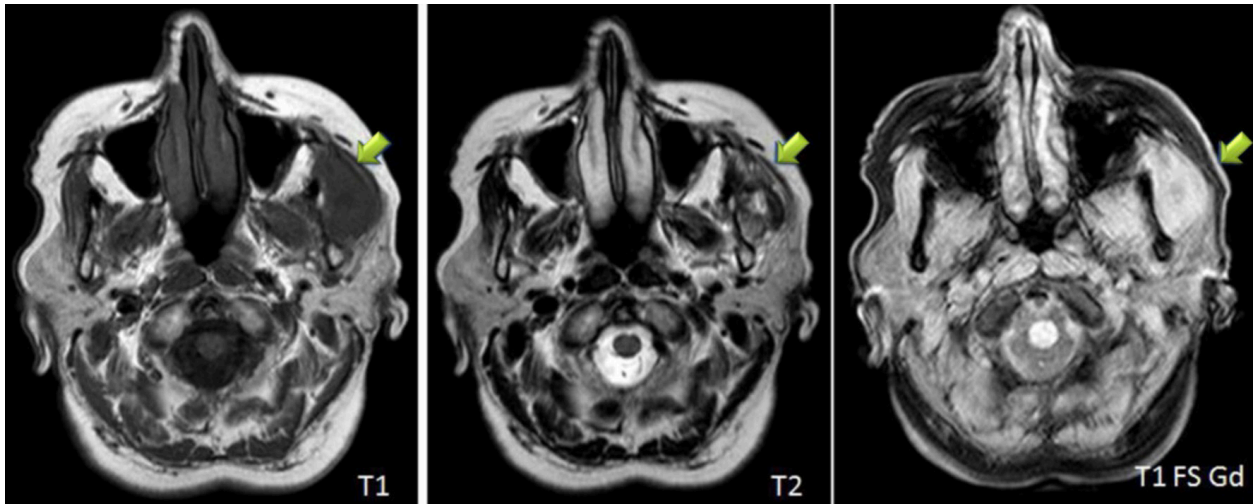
Deep fibromatosis of the left masseter muscle in a 43-year-old male. Axial MR images showing a isointense to muscle lesion on T1 weighted images, hiperintense in T2weighted images and avid contrast enhancement lesion on the left masseter muscle (arrows). It was biopsy proven to be a deep fibromatosis.
